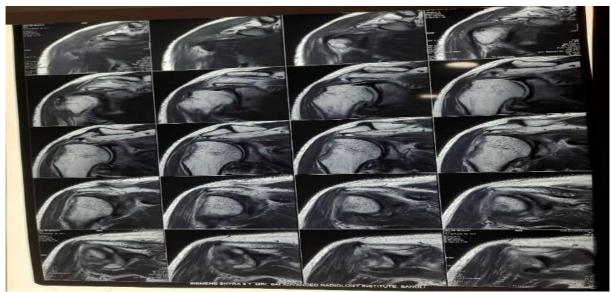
MRI findings of right shoulder revealed that displaced fracture pf greater tuberosity.
